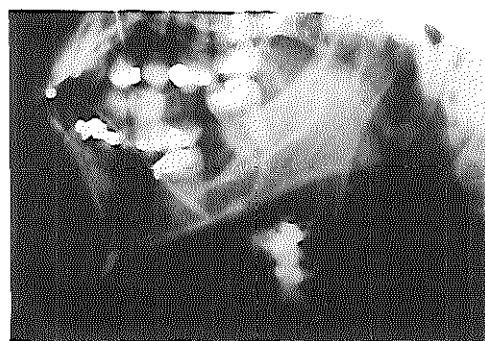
Lateral X-ray view of the submandibular region. Sialographic examination demonstrates marked dilatation of the submandibular duct.
